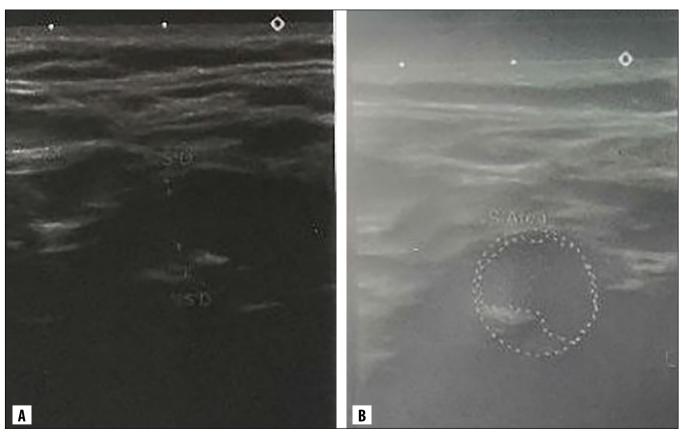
A) Carotid ultrasound. Common carotid artery; B) Carotid ultrasound. Bifurcation.
